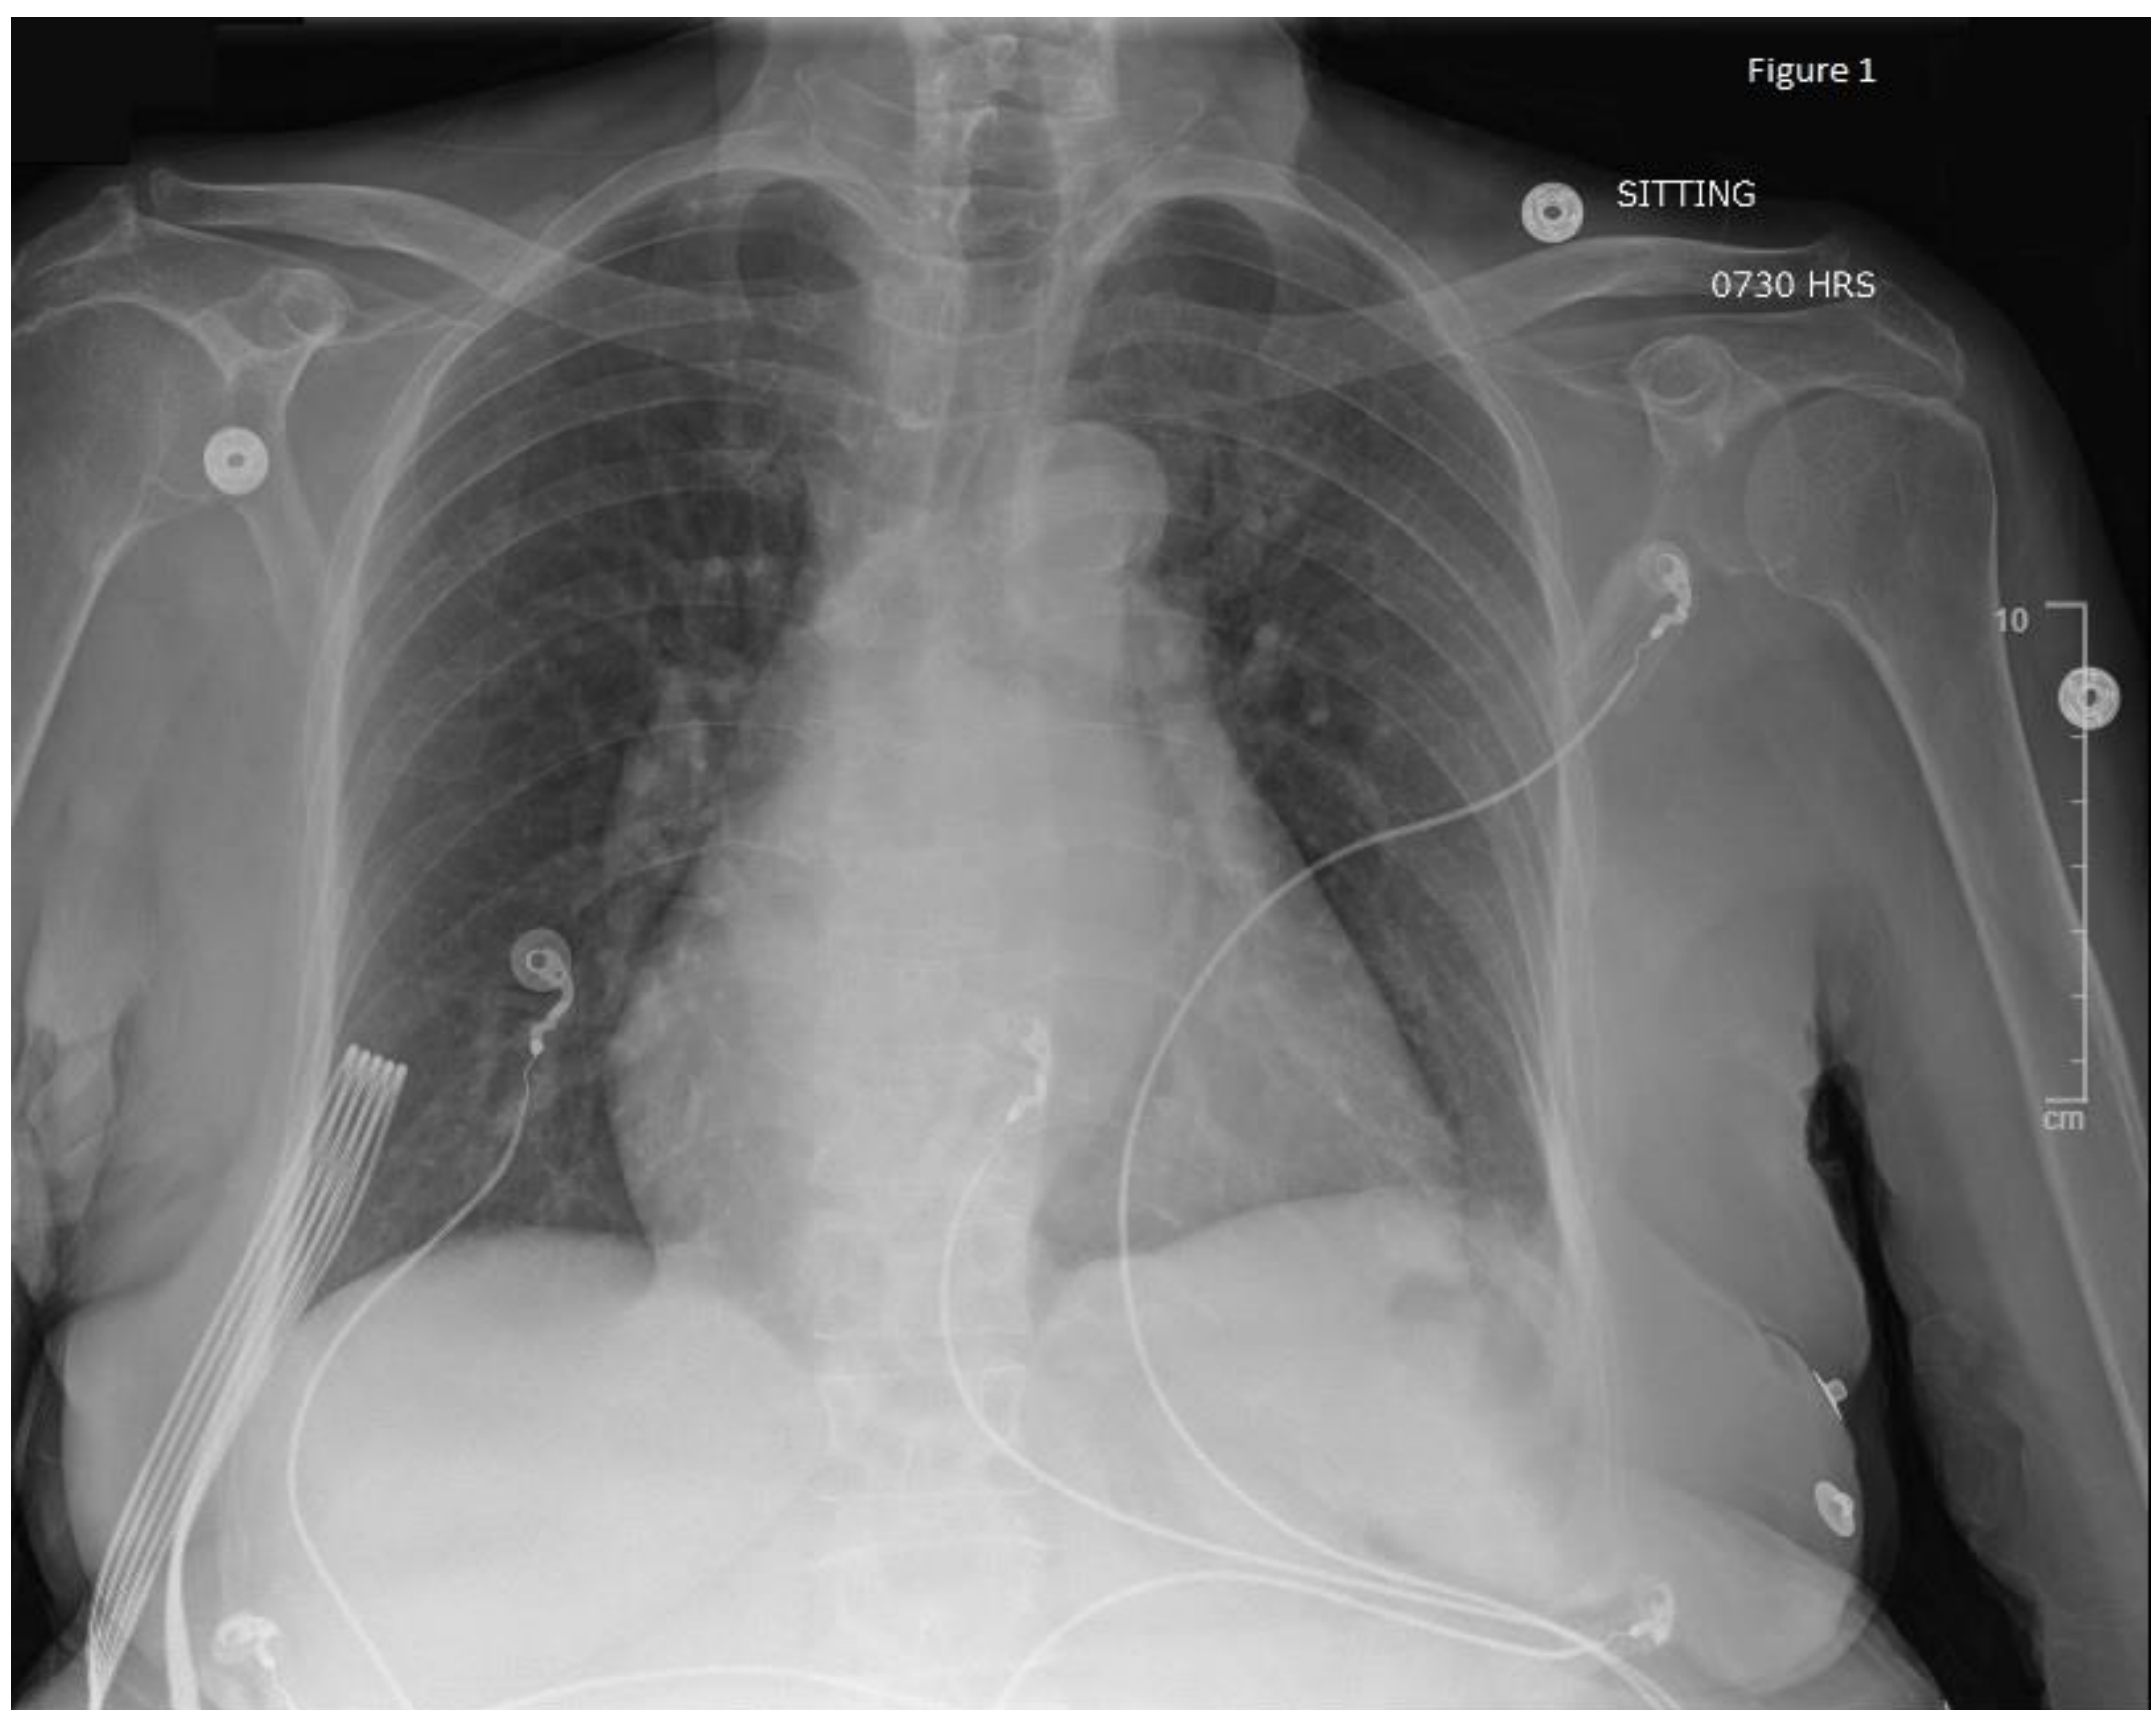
Chest X-ray of the patient on arrival
